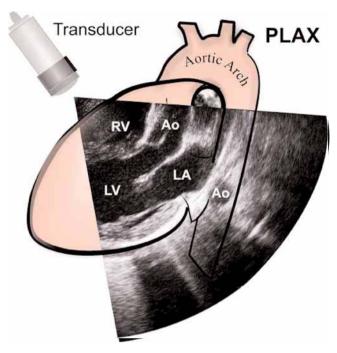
Parasternal long-axis (PLAX) (depth 20–24 cm). (See companion DVD.)
